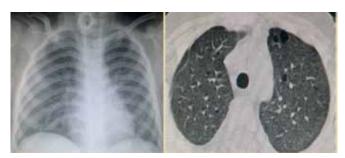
Chest radiograph and computed tomography (post-bilateral povidone-iodine pleurodesis) showing residual cysts but complete resolution of pneumothorax.
